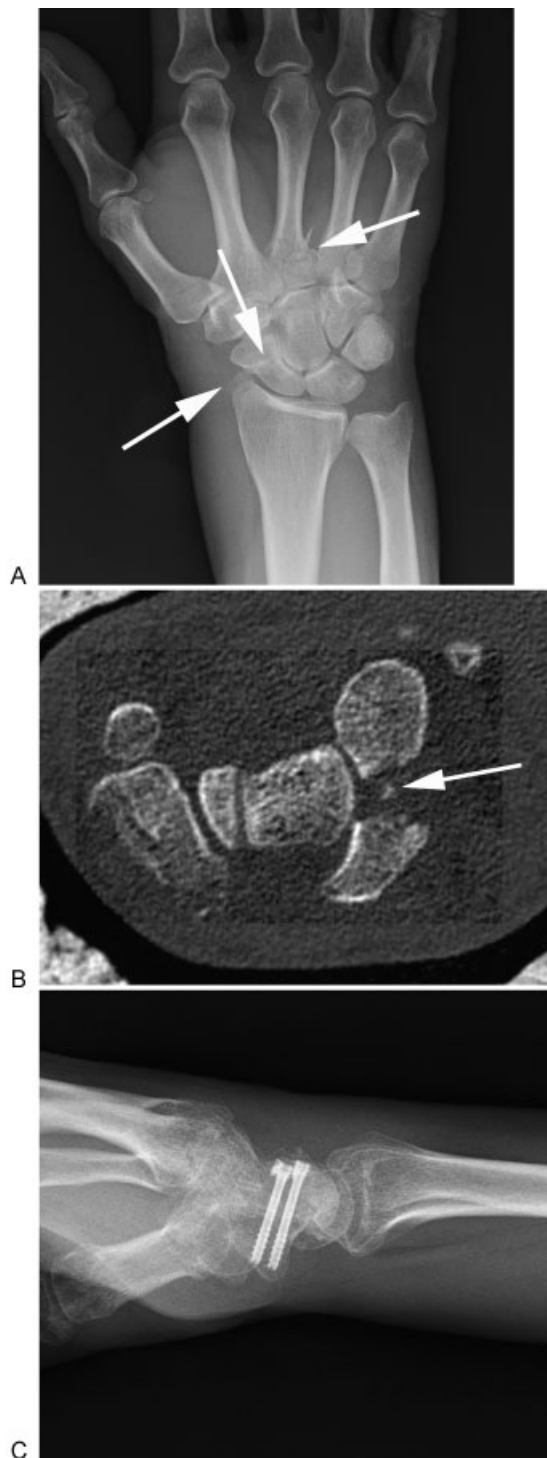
(A) Anteroposterior X-rays demonstrating a scaphoid waist fracture, plus a small radial styloid avulsion fracture, dorsal triquetral avulsion, and the 3rd metacarpal base fracture (arrows). (B) Axial computed tomography scan revealed a coronal waist fracture (arrow). (C) An open reduction internal fixation of the coronal scaphoid fracture with two dorsal to volar cannulated screws.
